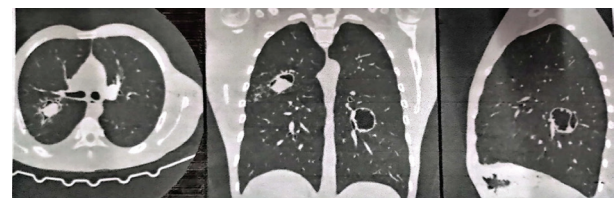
CT Chest showing Bilateral Cavitory Lung Lesions suggestive of Aspergilloma with endobronchial spread of infection with Right Middle Lobe Consolidation and Left Lung Cystic Bronchiectatic changes.
